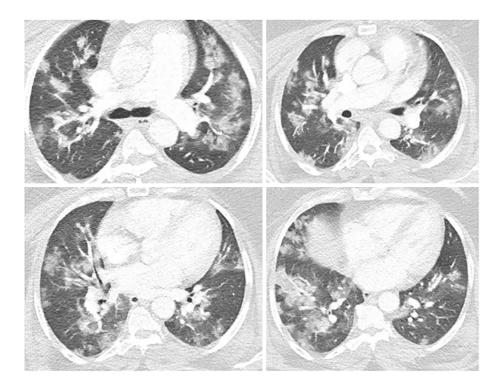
High resolution computed tomography images in a severe coronavirus disease 2019 patient showing the bilateral patchy ground-glass opacities with consolidations.
